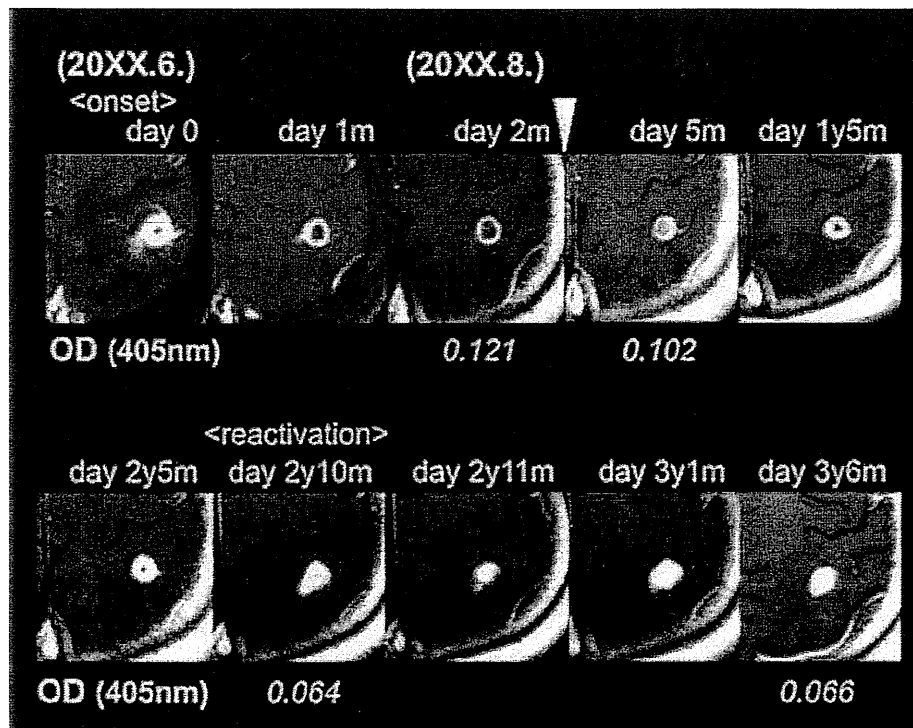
Time course of both T1-weighted MRI after contrast enhancement and antibody responses. ELISA data were shown as the OD values using recombinant chimeric antigen (cut-off OD value: 0.038).¹² Treatment with ABZ was introduced at arrowheads.
